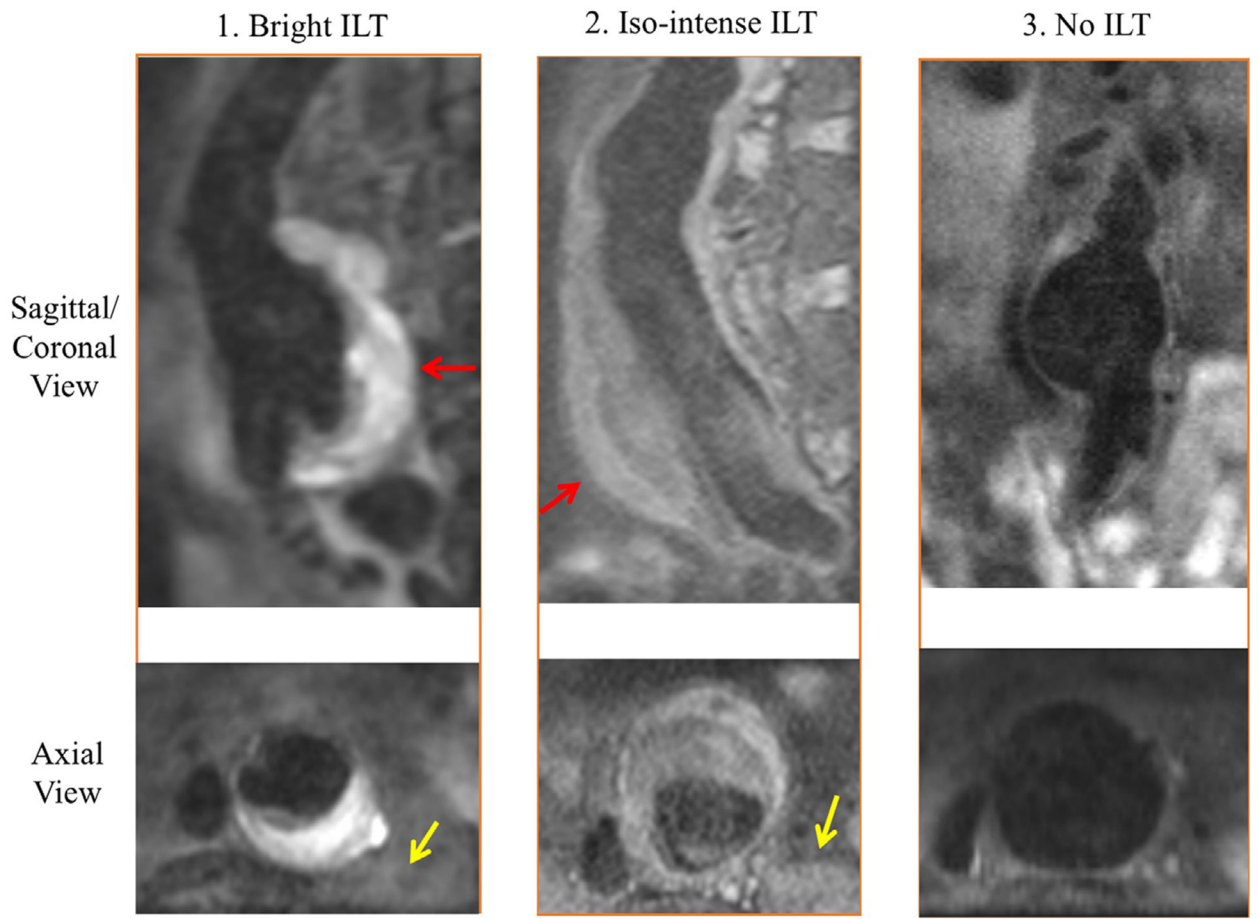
Different ILT types shown on black-blood MRI. Red arrows show the ILT. Yellow arrows show the psoas muscle.
